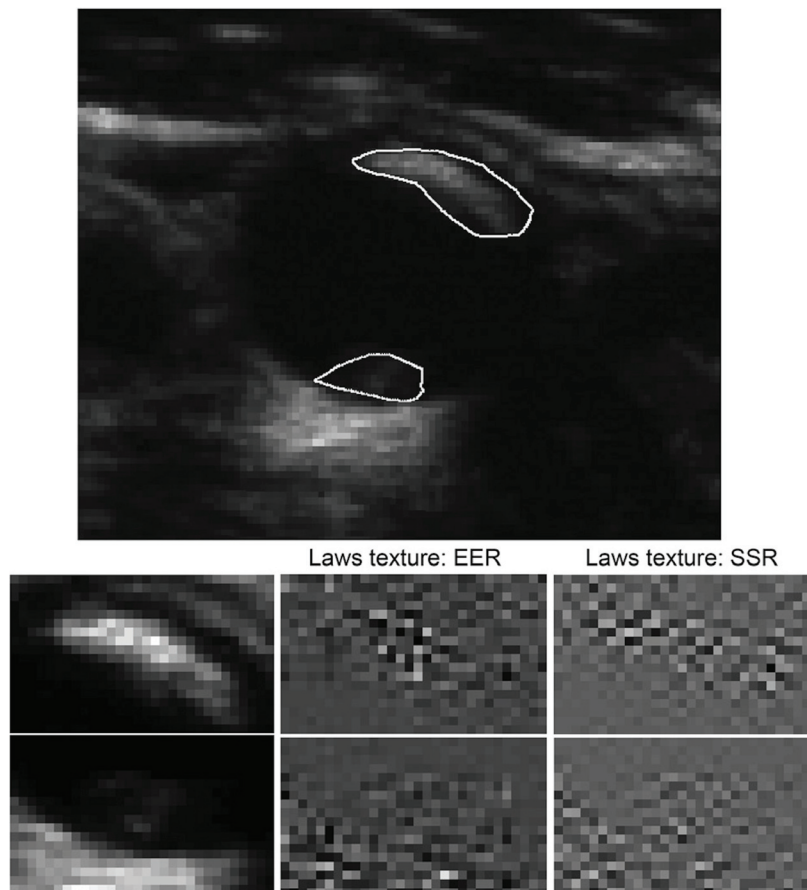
Carotid plaque texture. Texture for two plaques in the same vessel with a different appearance. In a total of 50 runs of sparse Cox regression (5× 10-fold cross-validation) on changes in texture, Laws edge-edge-ripple (EER) was selected in the model 49 times, and Laws spot-spot-ripple (SSR) 48 times. Reproduced by permission of Wolters Kluwer from: van Engelen A, Wannarong T, Parraga G, Niessen WJ, Fenster A, Spence JD, de Bruijne M: Three-dimensional carotid ultrasound plaque texture predicts vascular events. *Stroke* 2014, 45(9): 2695–2701.
